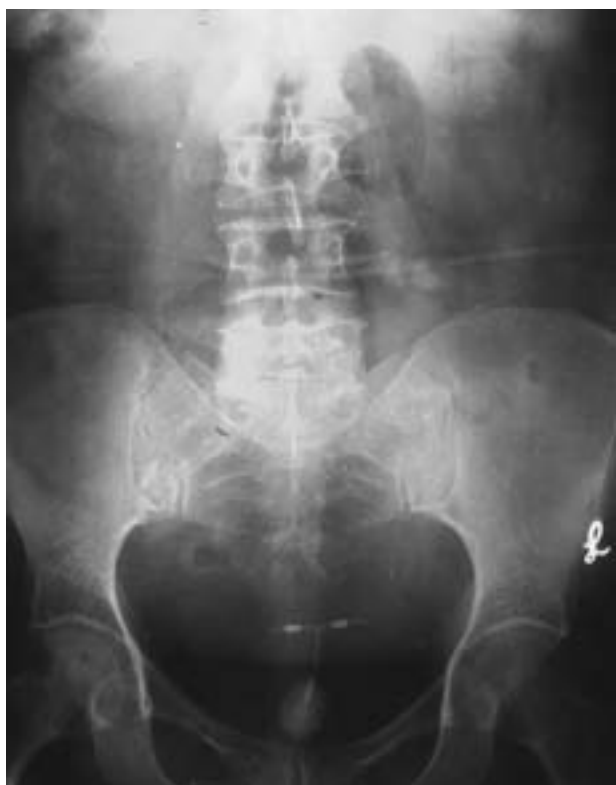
Plain abdominal radiography revealed a large calculus in the bladder and an intrauterine device.
